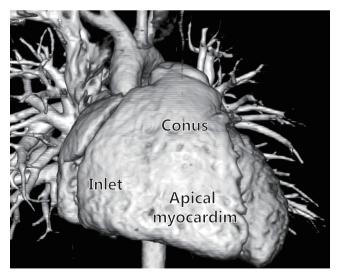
Three-dimensional computed tomography images of a normal heart showing the inlet, trabeculated apical myocardium, and infundibulum of the right ventricle.
